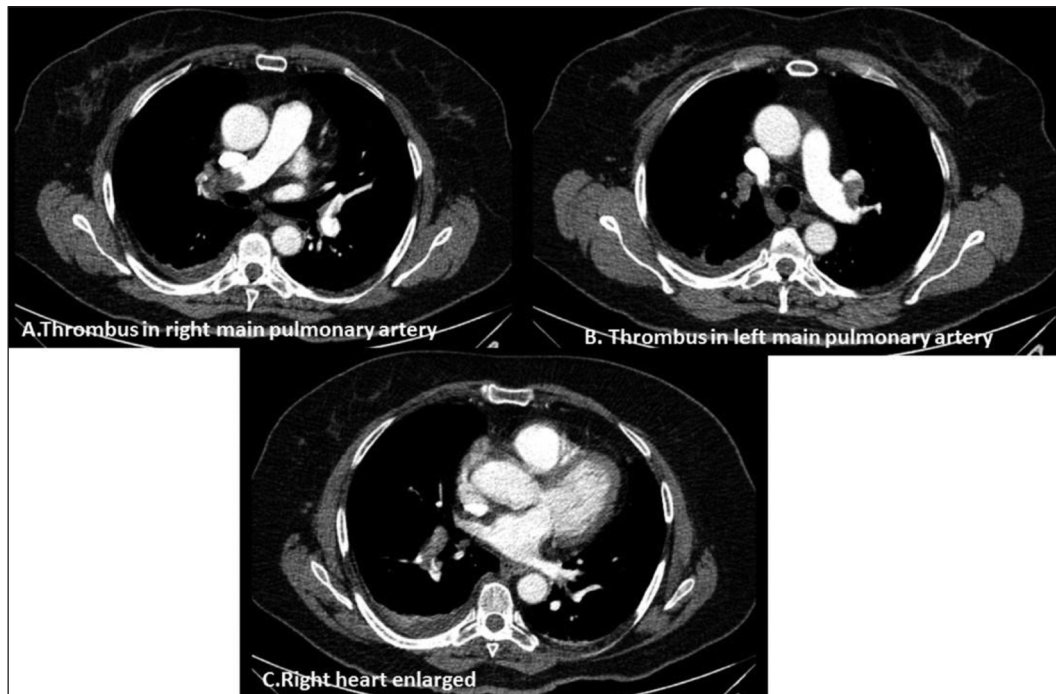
Computed tomography pulmonary angiography of the patient with massive pulmonary embolism. It was showing that massive thrombus into the left and right pulmonary arteries and dilated right ventricle presenting with the overloaded right heart.
